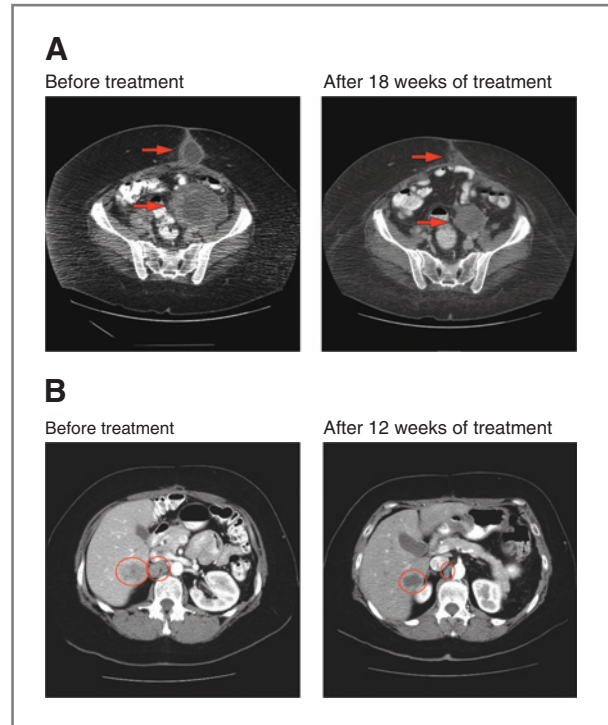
Computed tomography scans of responding patients. A, patient with ovarian cancer demonstrating partial response in pelvic and subcutaneous metastases. B, patient with ovarian cancer demonstrating partial response in liver and aorticaval metastases. Arrows or circles, locations of metastases.
